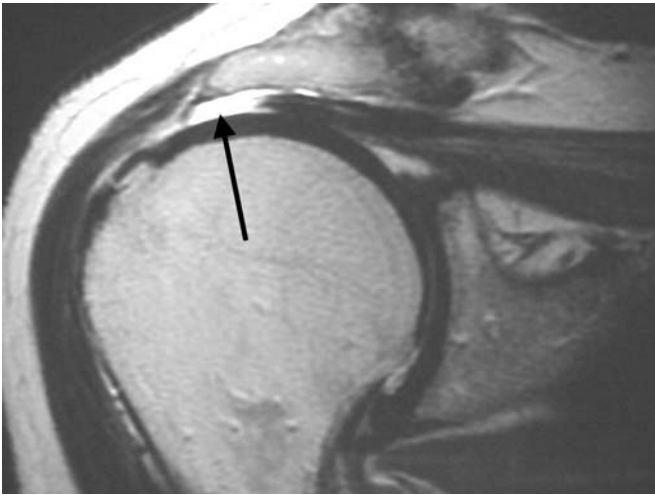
Coronal T2 MRI of the right shoulder. There is a full thickness tear of the supraspinatus tendon with fluid in the gap (arrow).
